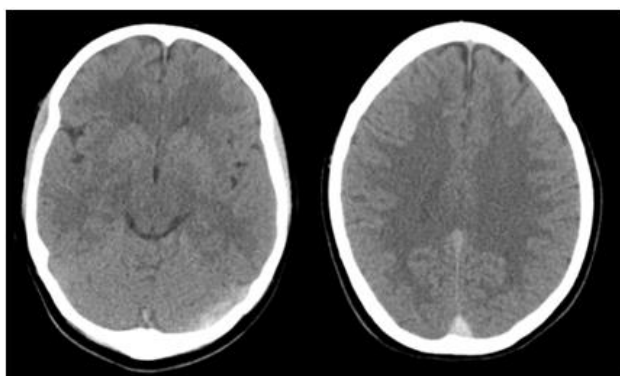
Native CT scan indicating CVST
